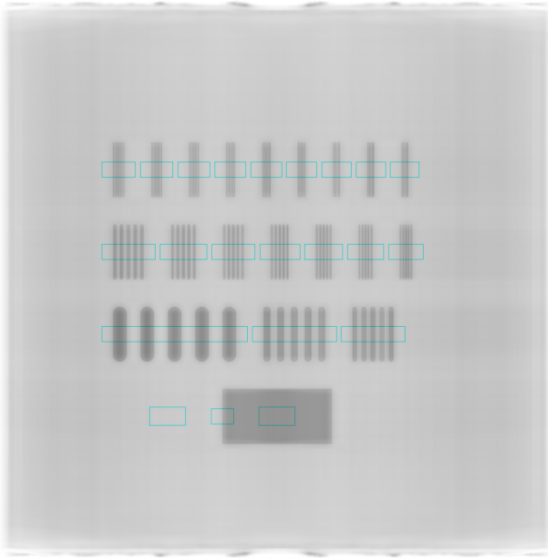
Slice of reconstructed data with resolution enhancement, magnification for high resolution images is 5x the magnification of normal CT.
